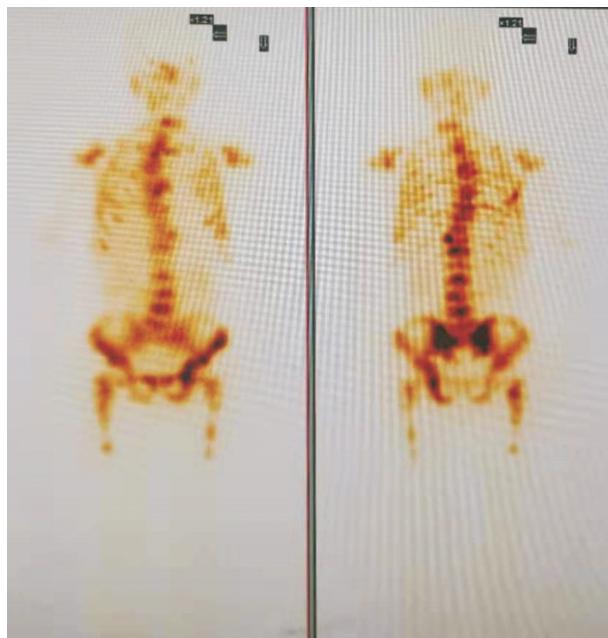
^{68}Ga -PSMA PET/CT 显示
